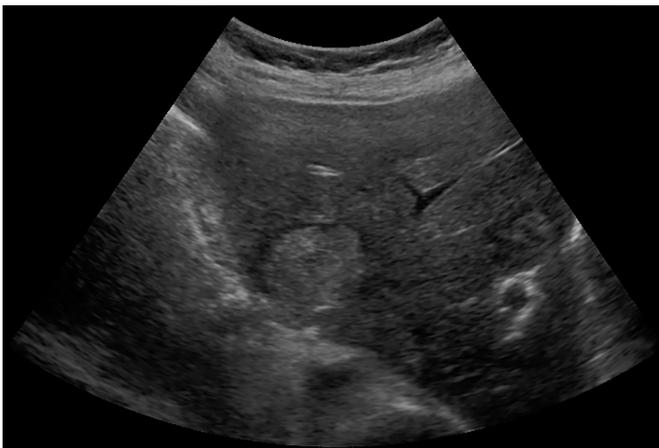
Conventional ultrasonography view of the liver lesions
